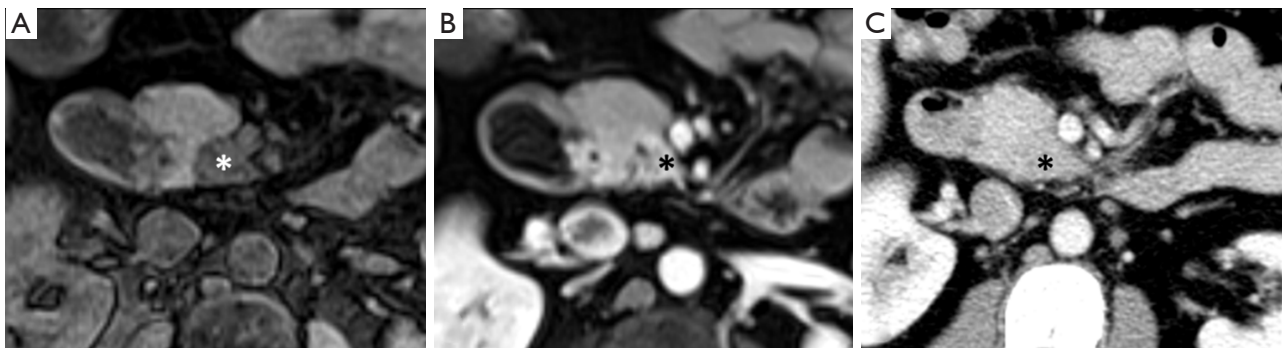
MRI and CT of non-contour deforming uncinus process pancreas mass. Axial (A) noncontrast and (B) arterial MR images in a 44-year-old woman reveal a non-contour deforming mass (asterisks) in the uncinus process of the pancreas, which is isodense and nearly indiscernible on (C) venous phase CT. MRI, magnetic resonance imaging; CT, computed tomography.
